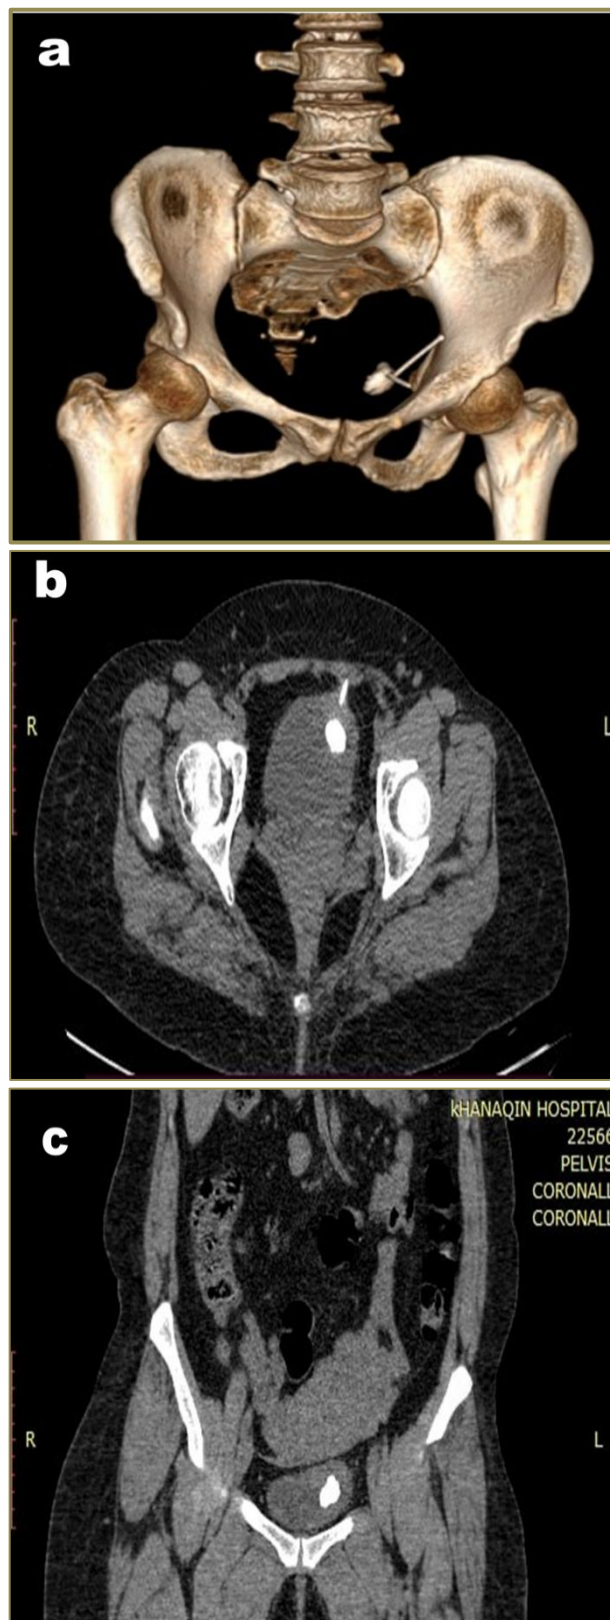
(a, b, c): Native abdominal CT scan showing migrated IUCD with intravesical stone and extravesical limb penetrating abdominal wall
